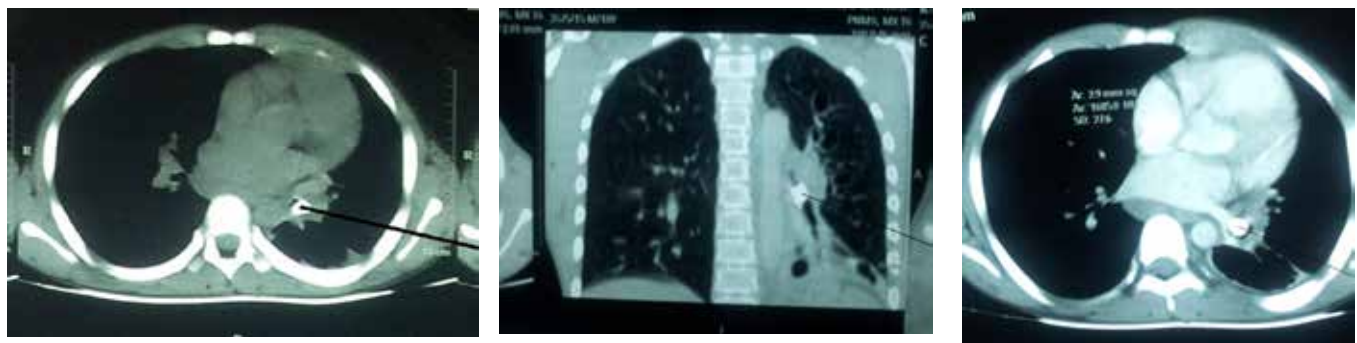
CT-Scan findings before intervention (bronchoscopy). Showing evidence of hyper-inflated right lung, left lower lobe atelectasis, mediastinal shift and a clear radio-opaque foreign body in the left main (arrowed) bronchus.
